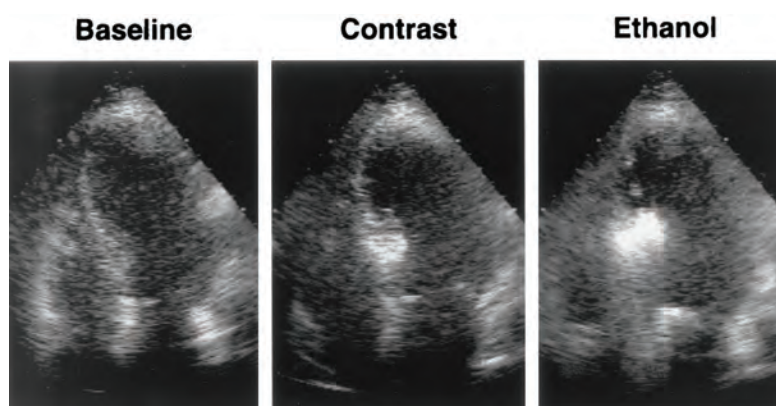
Myocardial contrast echocardiography of the hypertrophied septum after injection of sonicated albumin (Contrast) and ethanol (Reprinted with permission from Nagueh et al. [37]).
